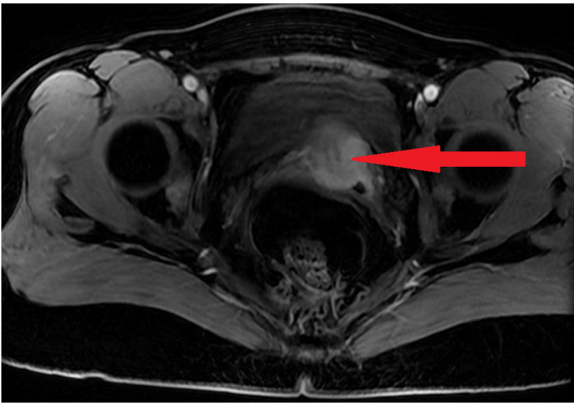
Initial pelvic MRI. The arrow indicates the location of the cervical metastatic lesion prior to treatment, which manifests as high signal intensity.
